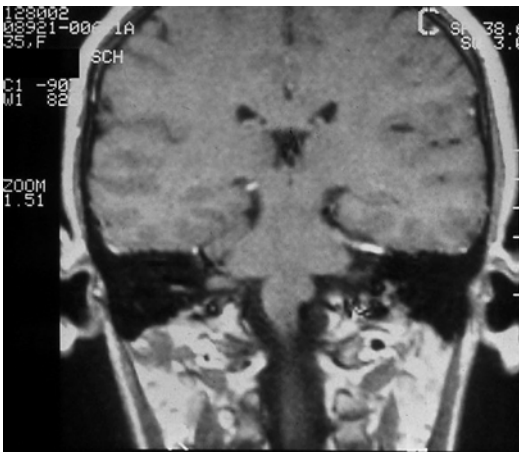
MR image of a patient with facial neuroma on the left side
